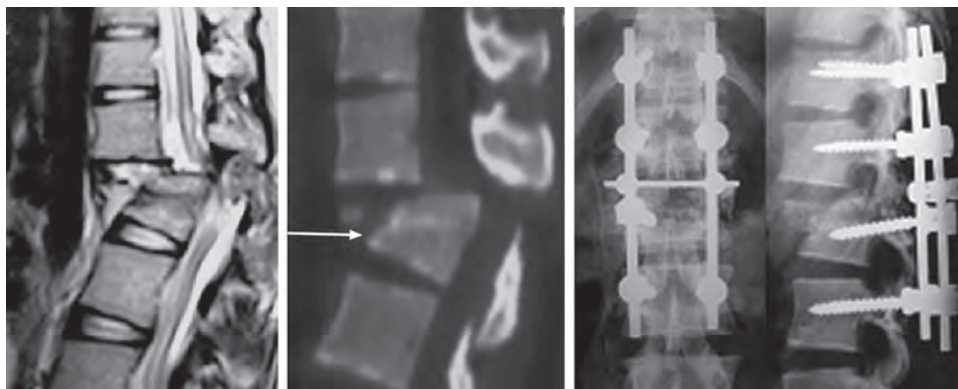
Sagittal T2 MR imaging of what looks like cord transaction (left). Note the severe canal compromise on CT (middle). This patient has improved from Frankel A immediately after injury to Frankel C in 4 months after extended short segment posterior instrumentation (right- post-operative radiographs), proving that he did not have a true transaction
